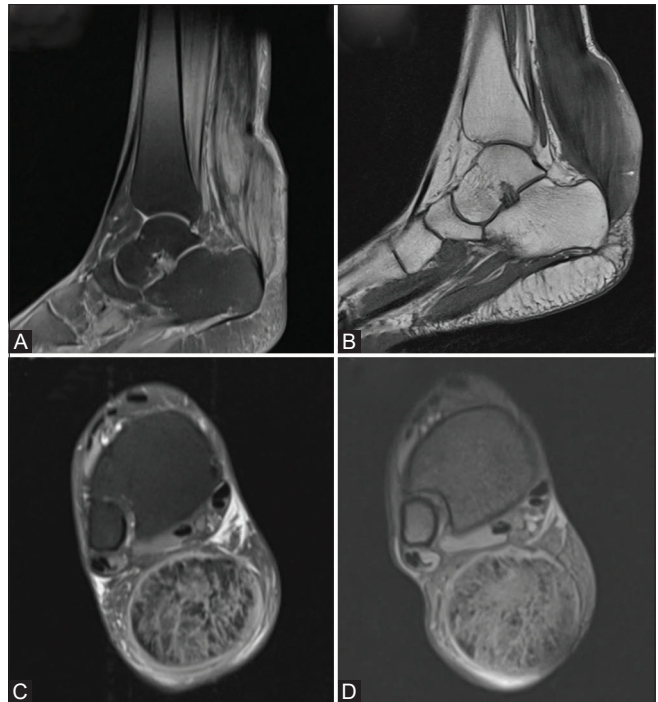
(A-D): Sagittal proton density image (A) and T1-weighted image (B) showing diffuse enlargement of Achilles tendon with axial proton density (C) and MEDIC (D) showing enlarged Achilles tendon with widely spaced tendon fibers interposed with fat (speckled appearance)
